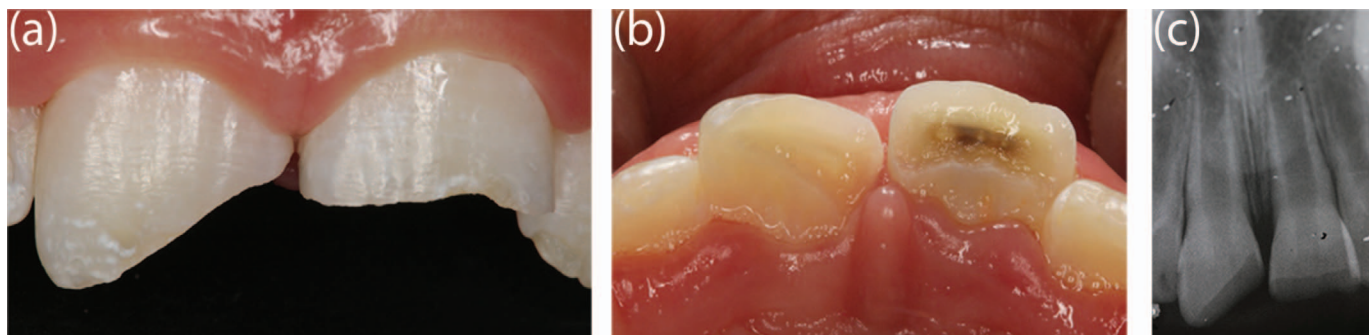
Clinical (a) and radiographic (b) evaluation of the fractured teeth.
